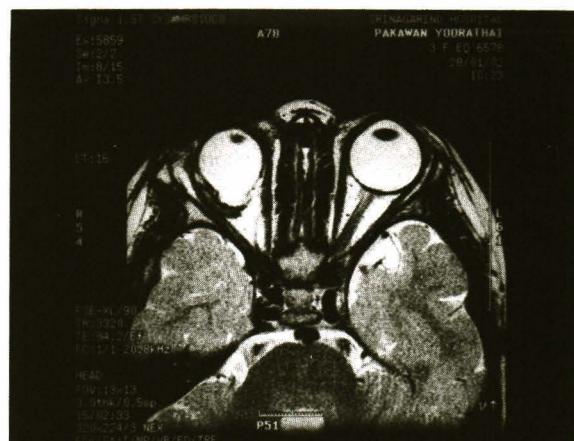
T2-weighted magnetic resonance imaging of the orbits showed a small-sized orbital cyst at 2 years after orbital aspiration.
